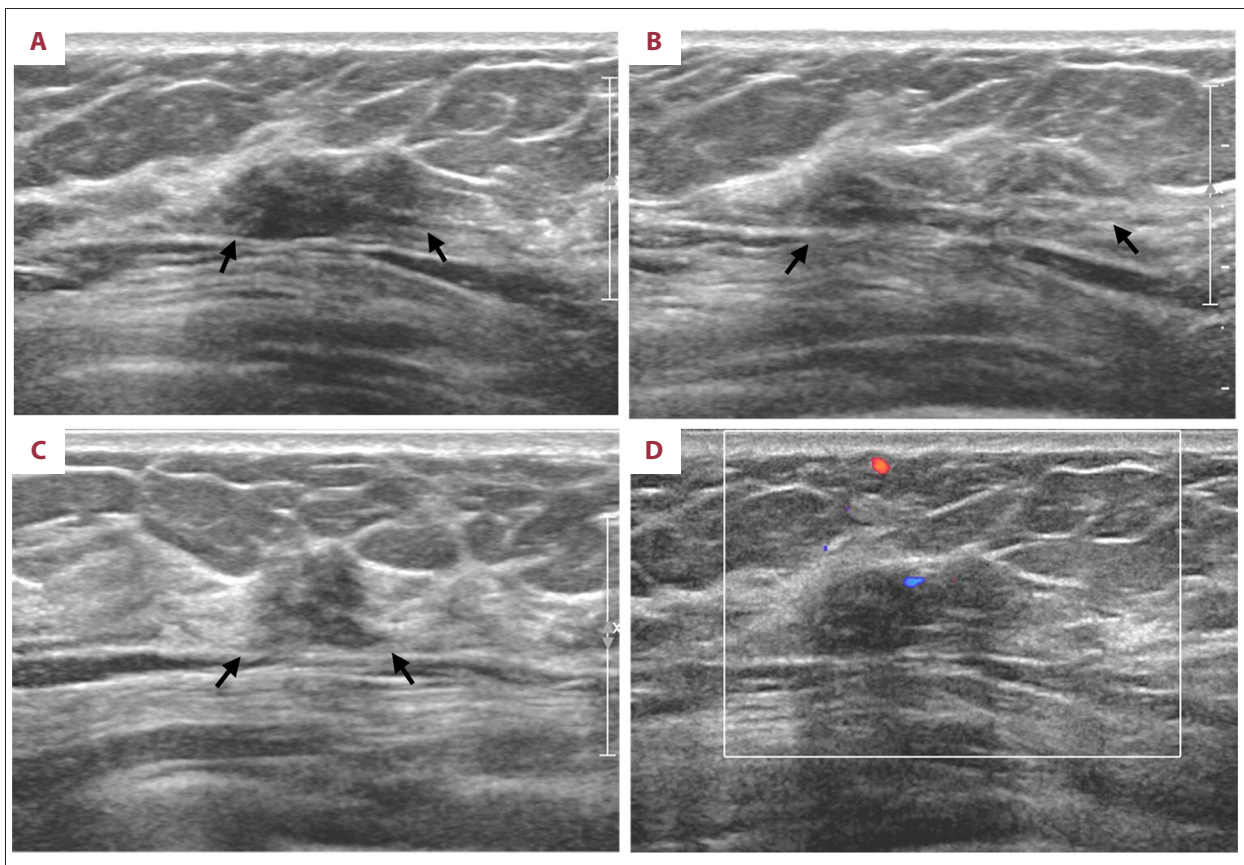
(A) Transverse, (B) radial, and (C) longitudinal gray-scale sonograms show focal indistinct hypoechoic area (arrows) in the right breast, which is discernable from the surrounding fibroglandular tissue, but does not conform to the definition of a mass. There are intervening normal fibroglandular tissues within the hypoechoic area. (D) Color Doppler sonogram shows a few spotted increased vascularity within the non-mass-like lesion.
